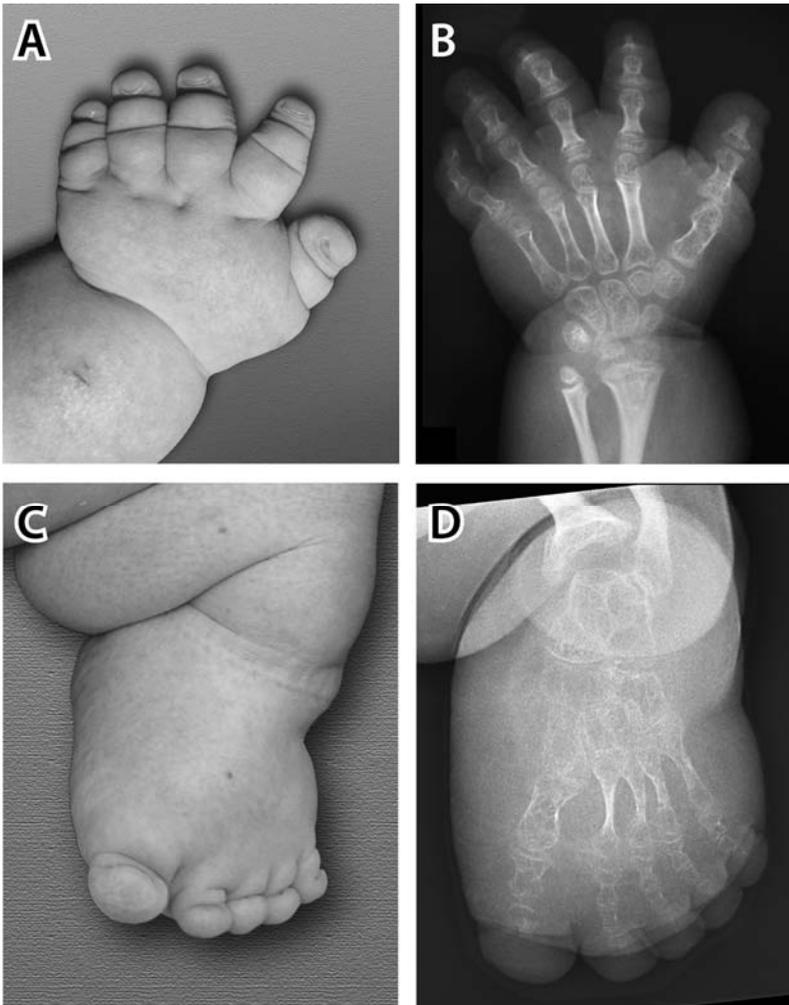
Radiographs of hands and feet in a 15 years old female. Small stubby hands and feet with hypoplastic nails (A,C) Severe shortening and thinning of all tubular bones including metacarpal and metatarsal bones, especially marked at the distal phalanges (B,D). Adapted with modification from Kovero et al.¹⁹
